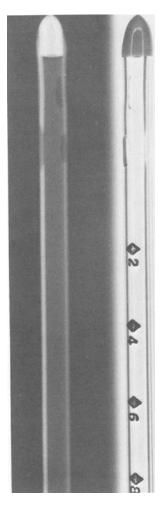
The radiograph of the chest tube (left) shows the similarity of the radiopaque tip to a bullet. The chest tube is shown on the right.
